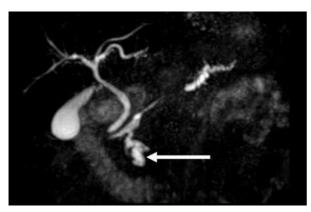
Cholangio-magnetic resonance image: 26 mm branch type IPMT located in the uncus (white arrow) concomitant with a Wirsung dilation of the pancreatic body.
